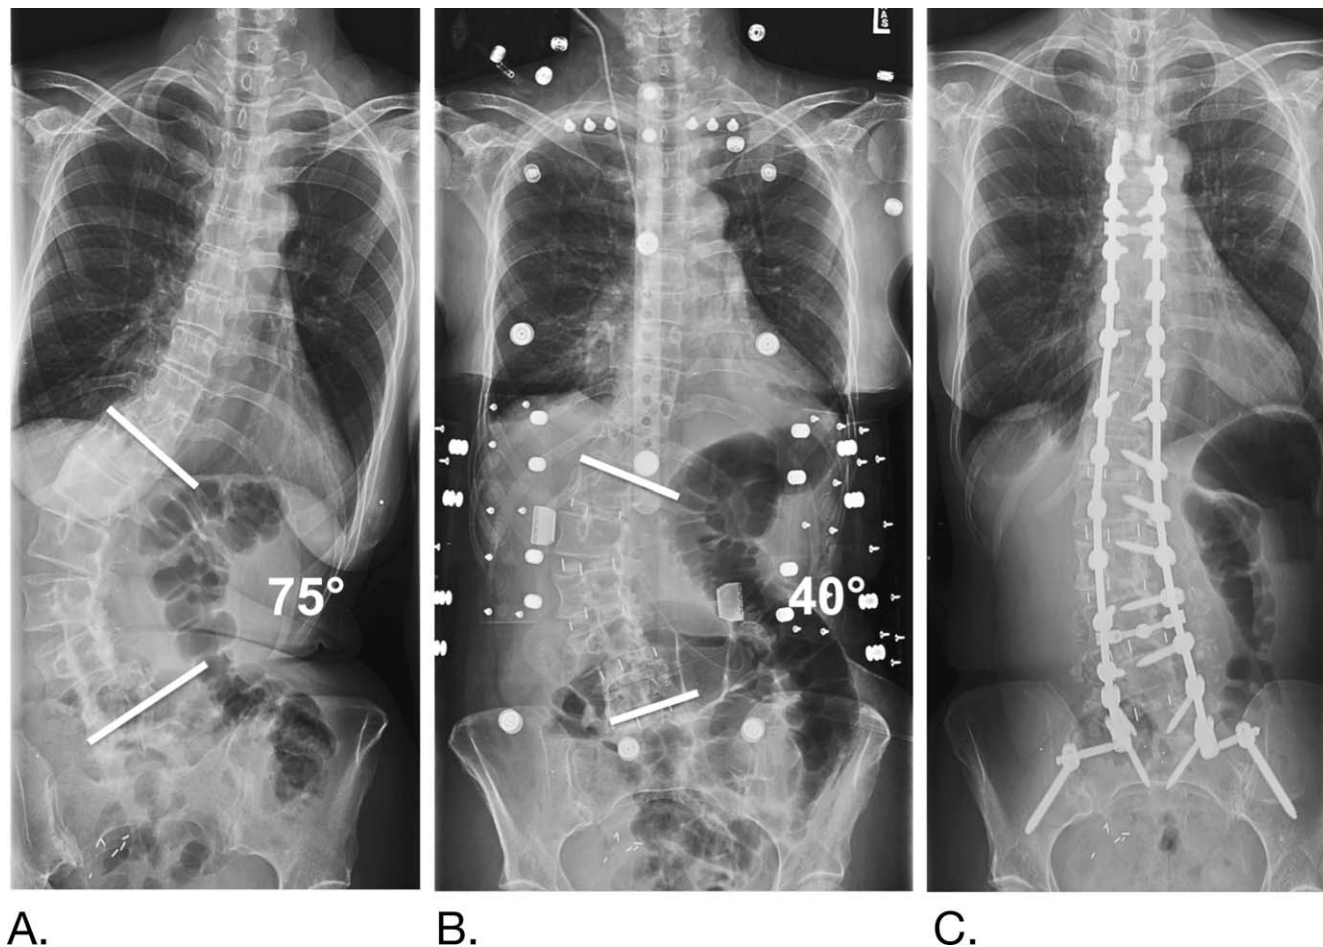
A: Preoperative x-ray of a patient with degenerative lumbar scoliosis showing a 75-degree lumbar scoliotic curve with lateral spondylolisthesis at L4-L5. B: X-ray of the same patient after the lateral (first) stage of the 2-stage procedure. The curve has been reduced to 40 degrees with the lateral procedures alone. C: X-ray of the same patient after the posterior instrumentation stage of the procedure. The scoliotic curve has been almost fully corrected. The sagittal balance has also been restored although it cannot be seen in this view.
